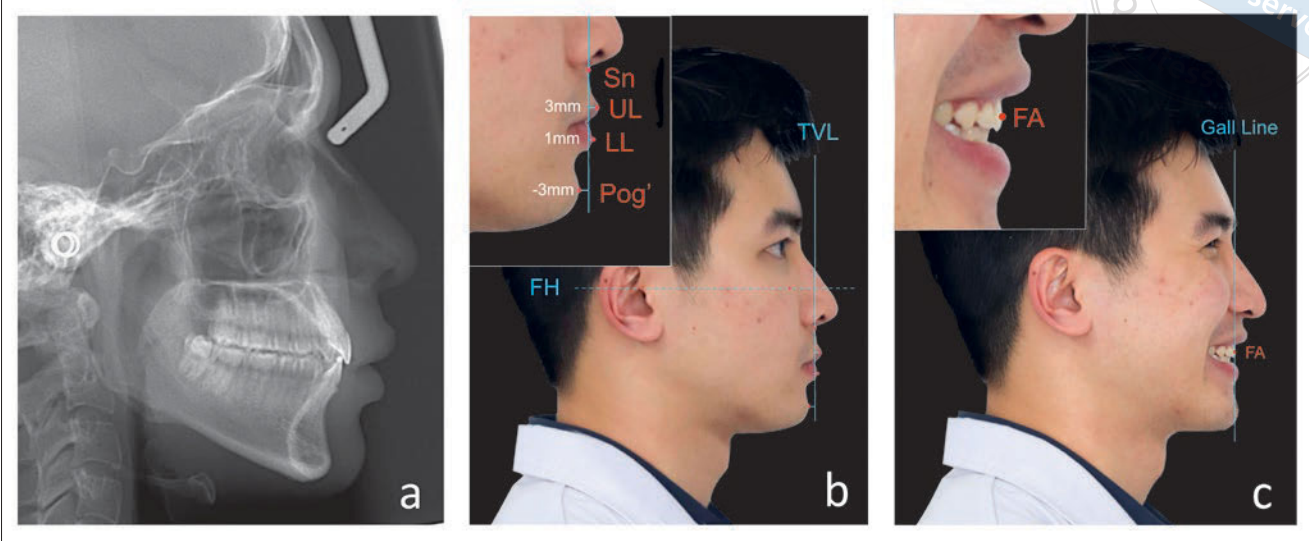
to c Lateral cephalometric radiograph (a), natural profile photograph (b) and smiling profile photograph showing the maxillary incisor FA lies on the GALL (c).
